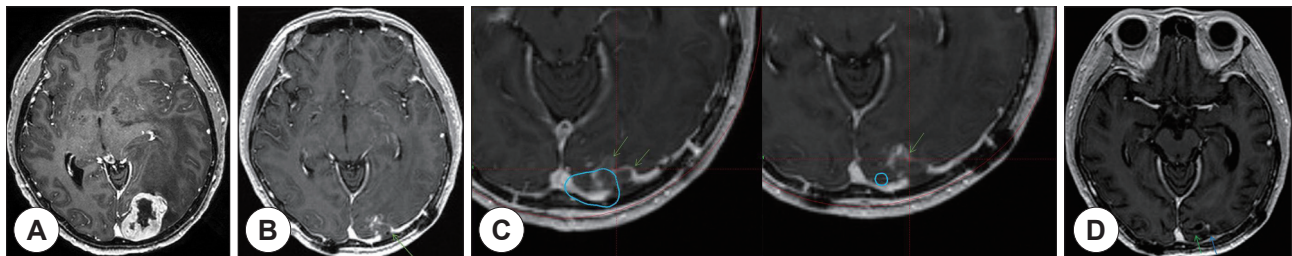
CASE F/56 lung cancer. A 56-year-old woman with known lung cancer. Gross total resection was performed, and she underwent radiosurgery. At Post-resection T1Gd Gamma Knife MRI (B), there was remnant tumor in the left occipital region (green arrow). We didn't cover the whole tumor cavity (green arrow) at the time of radiosurgery (C). After 14 months, she failed local control. The follow up contrast enhanced T1-weighted magnetic resonance imaging scans showed tumor recurrences (green and blue arrow) (D). After all, she received the repeat GKRS. Axial contrast enhanced T1-weighted magnetic resonance imaging scans before resection (A), Post-resection T1Gd Gamma Knife MRI (B), Gamma Plan snapshot at the time of radiosurgery (C), the follow-up MRI (after 14 months) (D).
